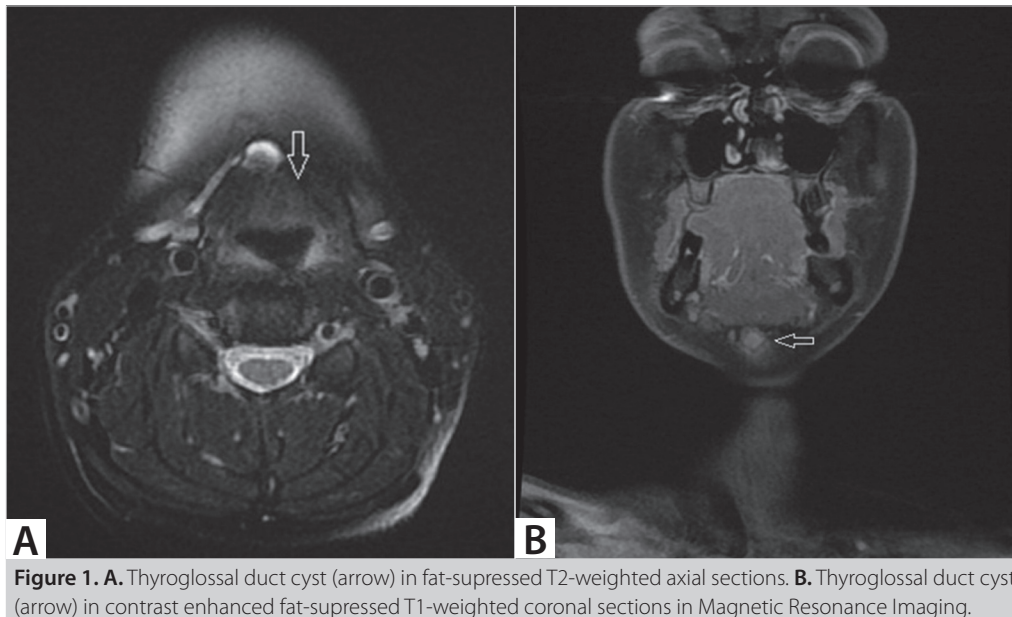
A. Thyroglossal duct cyst (arrow) in fat-suppressed T2-weighted axial sections. B. Thyroglossal duct cyst (arrow) in contrast enhanced fat-suppressed T1-weighted coronal sections in Magnetic Resonance Imaging.
